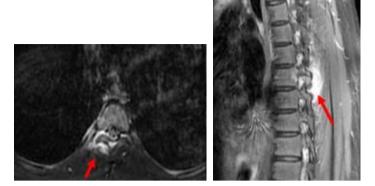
Extensive perilesional edema in MRI suggestive of aggressive nature.
